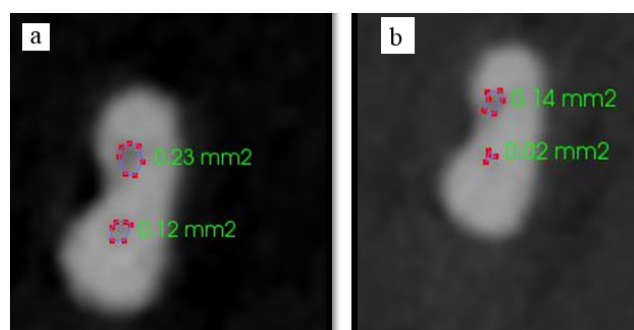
a: Pre-operative scan calculating area of the canal using CBCT; b: Post-operative scan calculating area of the canal using CBCT
